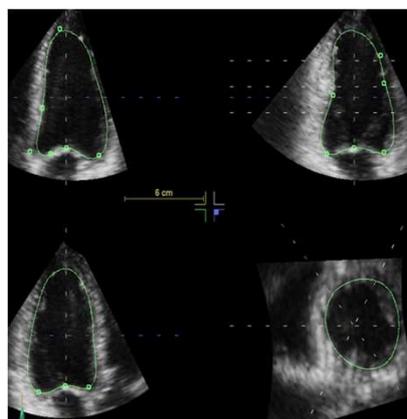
LVEF assessment via standard 3D-echocardiography (GE Vivid E9).
